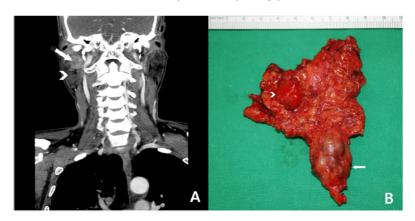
(A) Computed tomogram of the neck showing two lesions in the right parotid gland. A larger  $3.3 \times 2.2$  cm, irregularly circular, heterogeneously enhanced, focal necrotic mass (arrow) is in the more superior and deeper portion of the right parotid gland, and a smaller  $1.7 \times 1.5$  cm, well-defined, homogeneous, slightly enhanced, mass (arrowhead) is located in the more inferior and superficial portion. (B) The surgical specime showing two morphologically distinct tumours, the larger one in the deep lobe of the parotid gland (arrow), and the smaller one in the superficial lobe (arrowheads).
